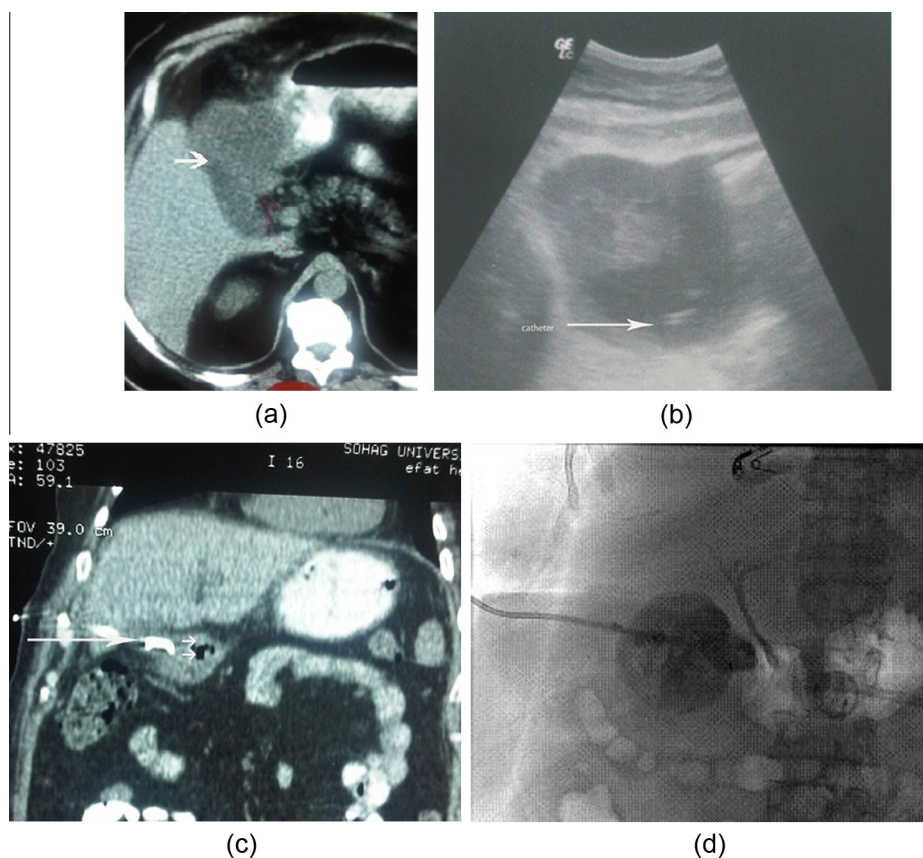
76-year-old man presented with upper abdominal pain and tenderness, as well as with fluctuating fever and progressive leukocytosis. The patient's WBC was 16,000 over the course of 10 days. CT scan (a) showed a perforated gallbladder with pericholecystic fluid collection (arrow). The patient had coronary artery disease with ischemic cardiomyopathy and an ejection fraction (EF) of 23%; the patient refused surgery. (b) Ultrasound-guided insertion of an 8.5 French pigtail catheter (arrow) was carried out following diagnostic aspiration of the sub hepatic fluid collection, and another catheter was placed in the gallbladder (not shown). Then, 10 days later, the catheter output from the sub hepatic fluid collection declined to about 5 mL/24 h and the patient's WBC declined to normal. Coronal CT scan (c) showed resolution of the fluid collection and the presence of few air bubbles (small arrows); the catheter (long arrow) was later removed. (d) Cholecystogram in a different patient following the quiescence of inflammation showed a patent cystic duct. Finally, a cholecystostomy catheter was removed and no further management was carried out for this patient.
